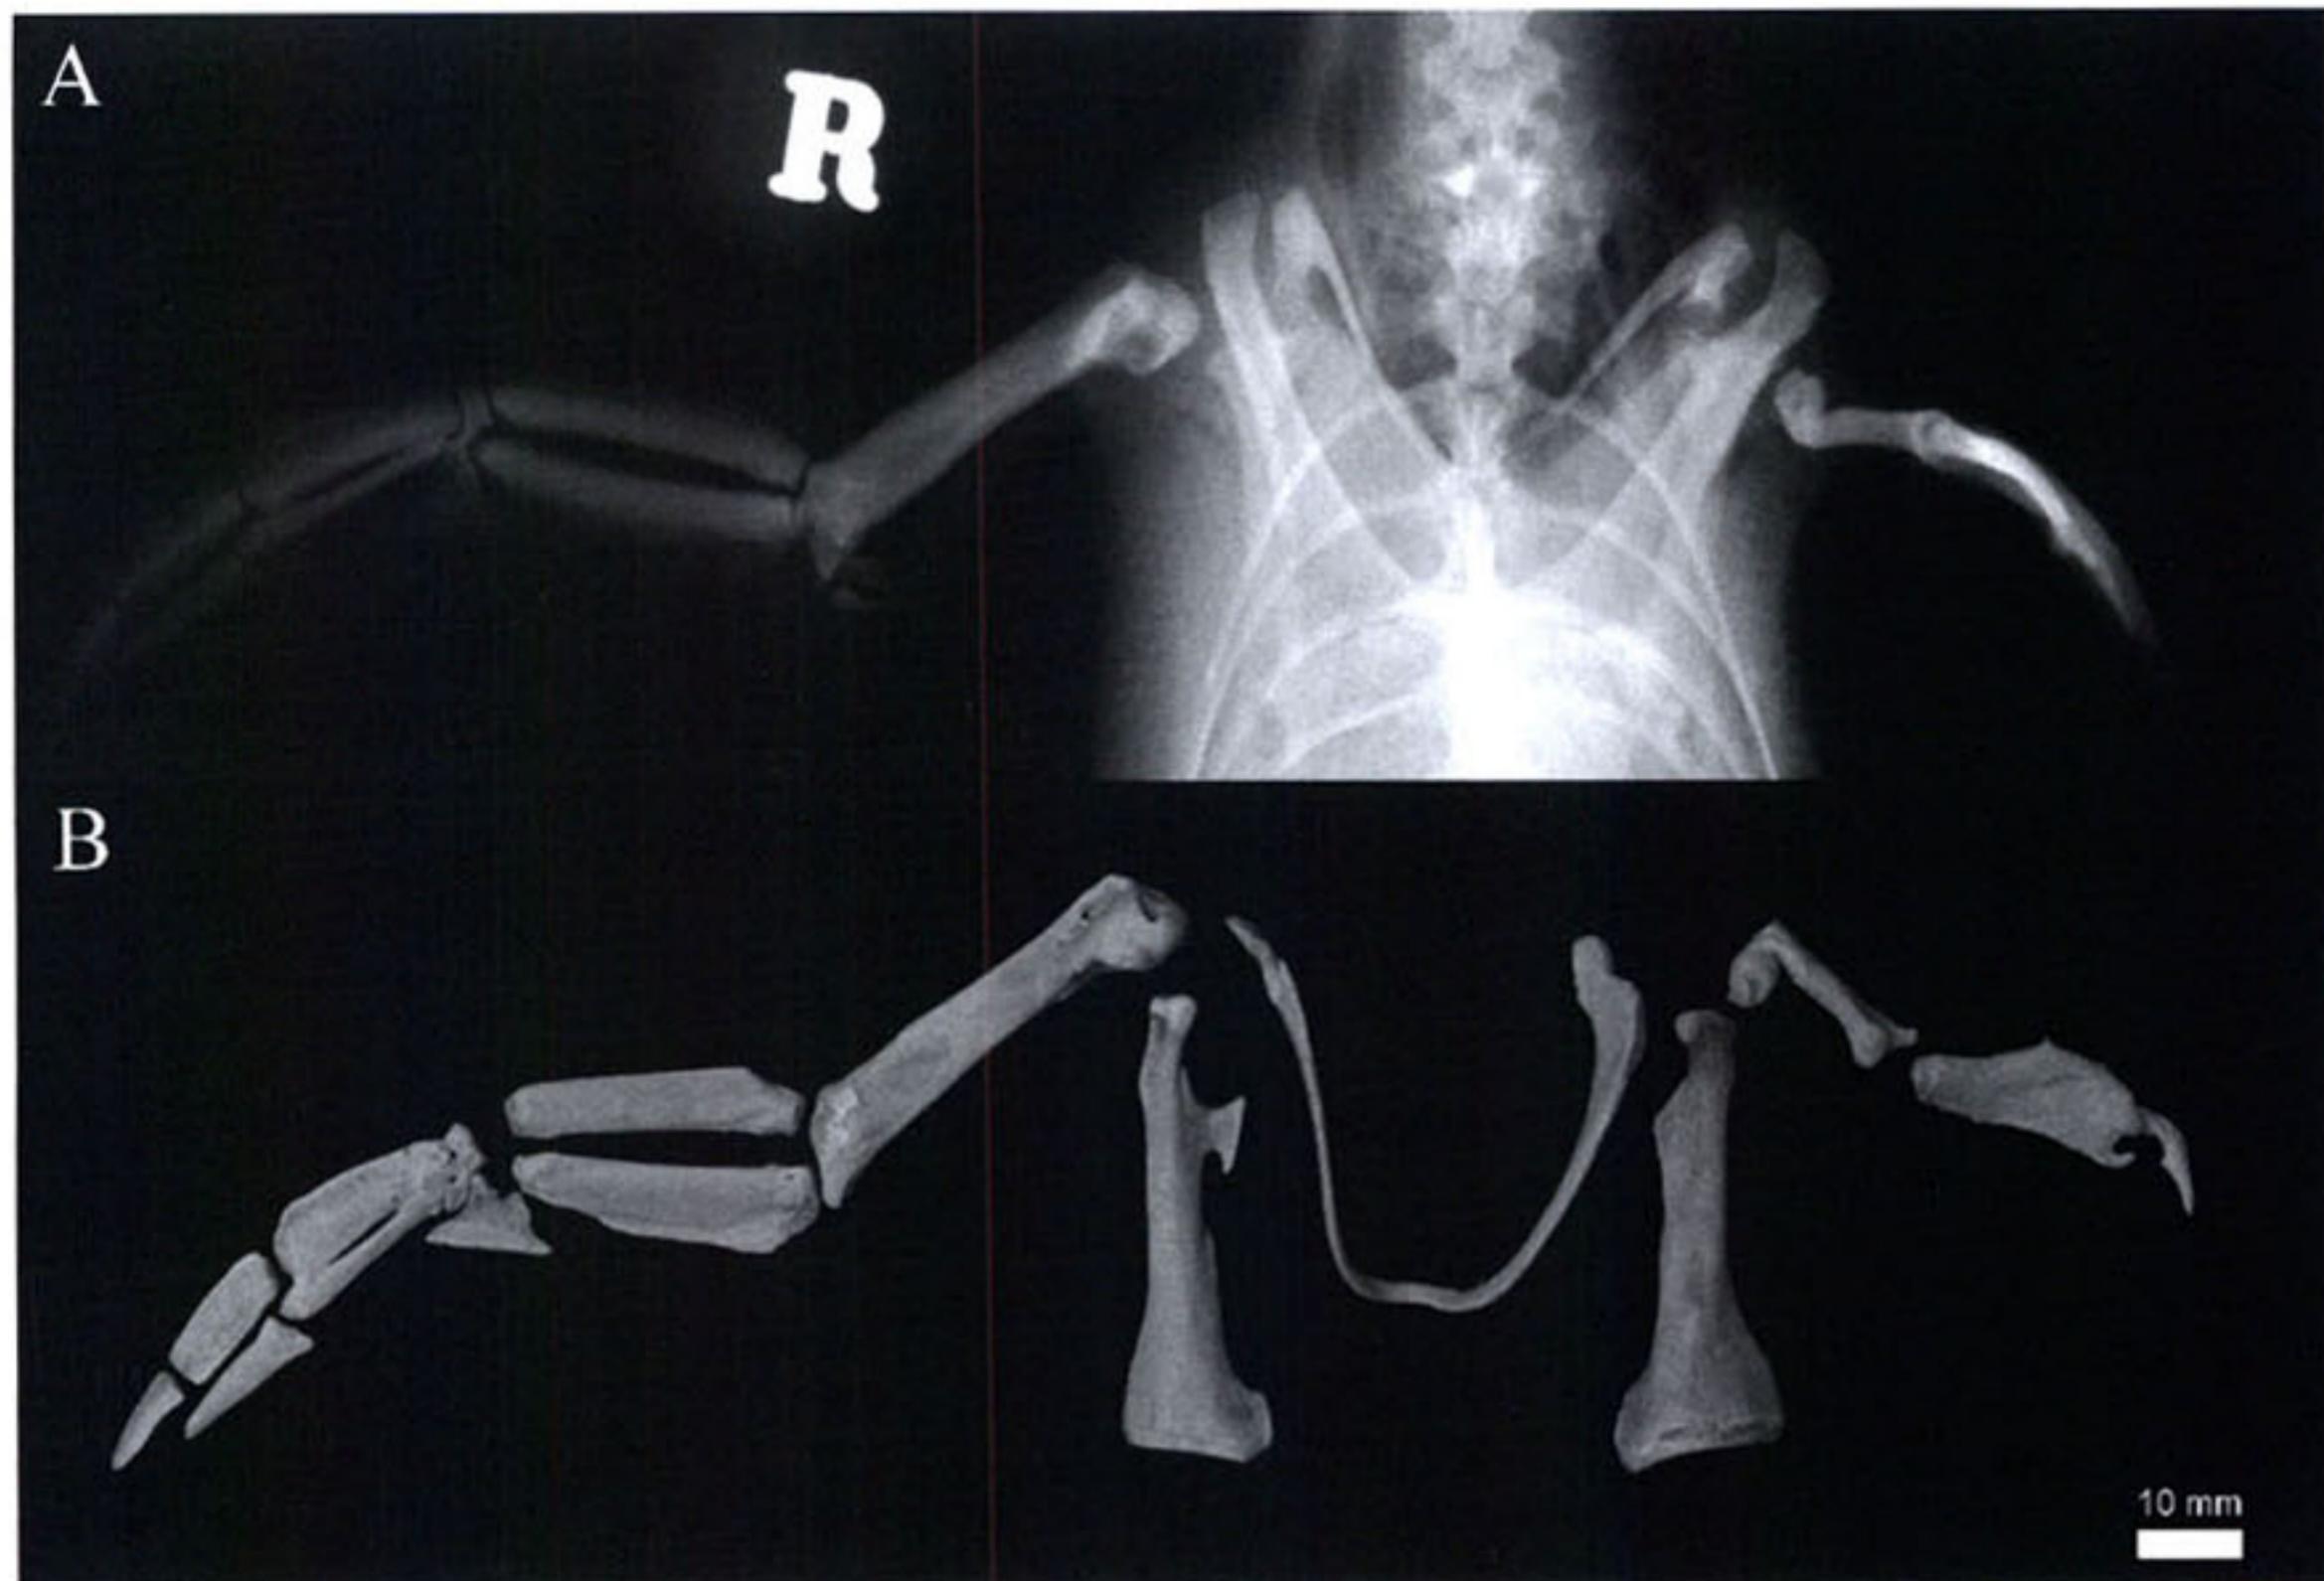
Ventrodorsal radiograph (A) of the bird shown in Figure 2 and an anatomical preparation of the pectoral girdle without the scapulae (B). Both figures demonstrate a markedly shortened and distorted left humerus and metacarpophalangeal synostosis, distortion, and phalangeal aplasia. Hypoplasia of the procoracoid process is evident on the medial aspect of the left coracoid.
